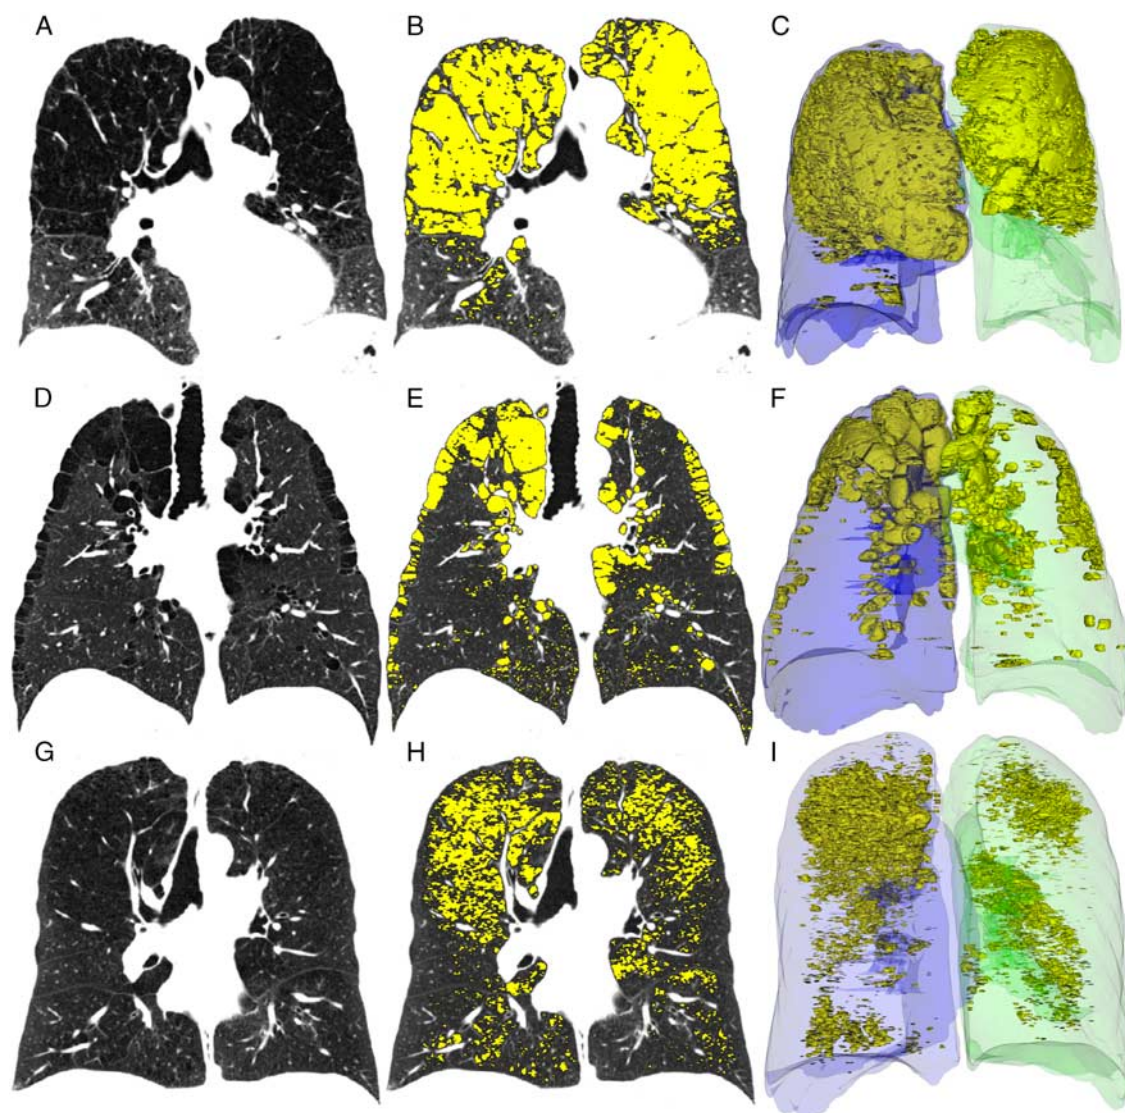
A–C, CT of a 71-year-old female COPD patient (subject S1), GOLD status 3. Most of the emphysema (yellow) is localized in the apical regions. Insp_{-950} for the whole lung is 41%, Insp_{-950} for RUL, RML, RLL and LUL, LLL is 66%, 35%, 7% and 60%, 2%, respectively. D–F, CT of a 50-year-old male COPD patient (S2), GOLD status 1. Emphysema (yellow) is predominantly localized in the cortical regions of the lung. Insp_{-950} for the whole lung is 12%; 73% of the emphysema is in the cortical regions. G–I, CT of a 57-year-old female COPD patient (S3), GOLD status 3. Emphysema is mainly localized in the medullary lung regions. Insp_{-950} for the whole lung is 14%; 80% of the emphysema is in the medullary regions. COPD indicates chronic obstructive pulmonary disease; LLL, left lower lobe; LUL, left upper lobe; RLL, right lower lobe; RML, right middle lobe; RUL, right upper lobe.
